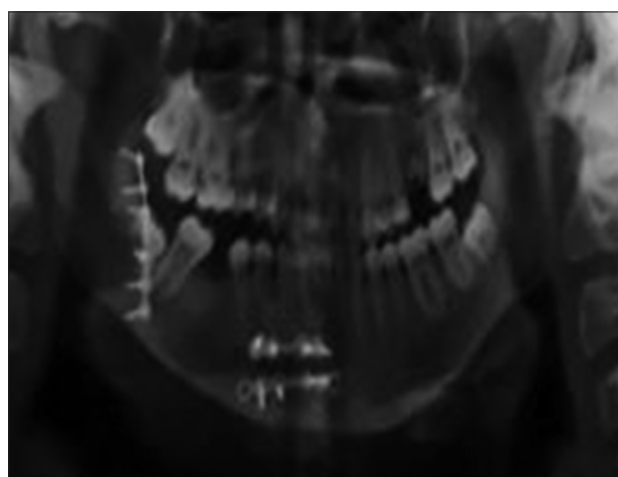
6 months orthopantomogram
